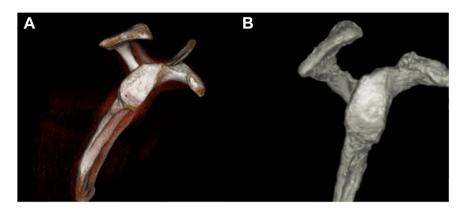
Examples of the (A) 3D CT and (B) 3D MRI of the glenoid utilized by the 11 senior shoulder surgeons. 3D, three-dimensional; MRI, magnetic resonance imaging; CT, computed tomography.
